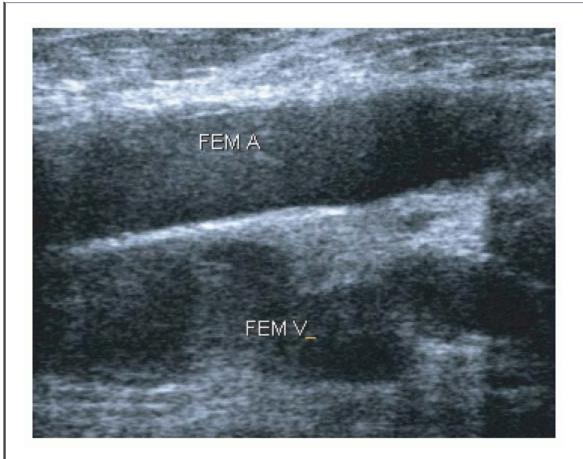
A sagittal view ultrasound of the femoral artery and vein. The vein (deep to the artery) has a ragged luminal edge with hyperechoic regions within the lumen. These are changes secondary to a propagating DVT.
